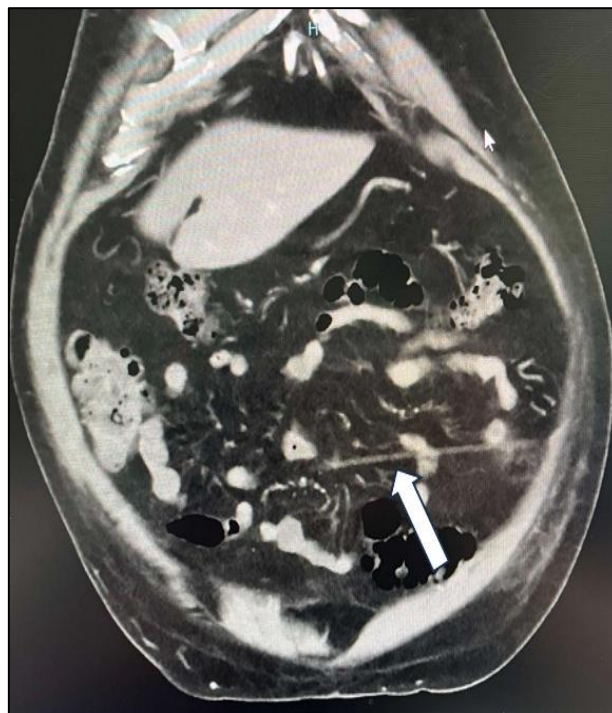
Coronal contrast enhanced CT image performed one month following the appendicectomy showing the ligature tube sheath lying horizontally across the left side of the abdomen (white arrow).
